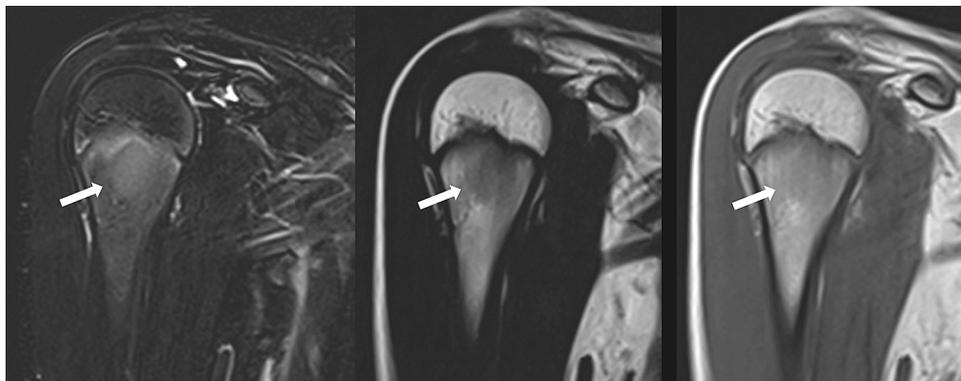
Right proximal humerus in a 14-year-old boy, showing a) an area of increased signal on T2 Dixon water-only (arrow). b) T2 Dixon fat-only reconstruction shows a well delineated corresponding low signal area (arrow). c) The T1-weighted image displays a lower signal as well, but less well demarcated than the fat-only Dixon image (arrow).
